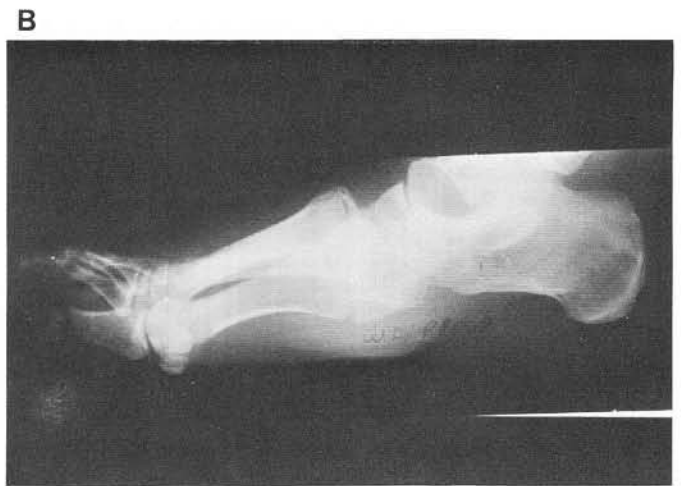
A, B. Radiographs show Charcot tarsometatarsal and intertarsal joint destruction.
